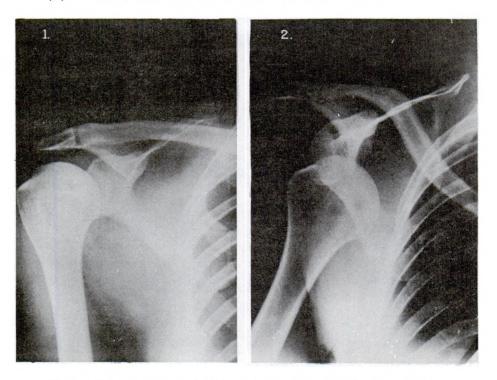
X-rays of (1) Normal joint and (2) Dislocated joint.
